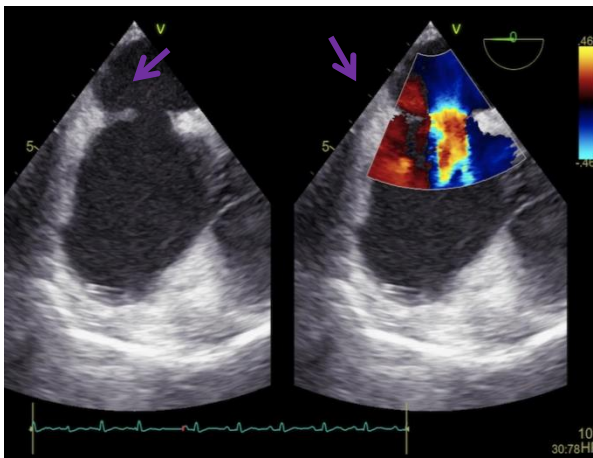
Transesophageal echocardiography showing secundum ASD left to right shunt
